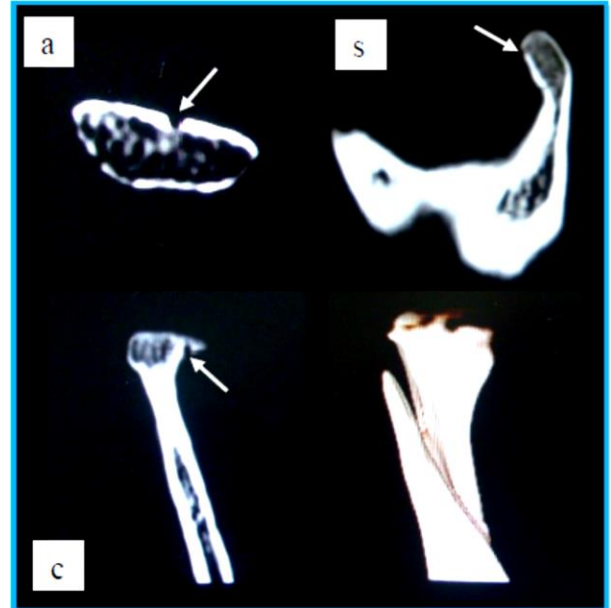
Cropped CT images of the same condyle demonstrating the lesion on anterosuperior surface in axial (a), coronal (c) and sagittal (s) sections (arrows)
